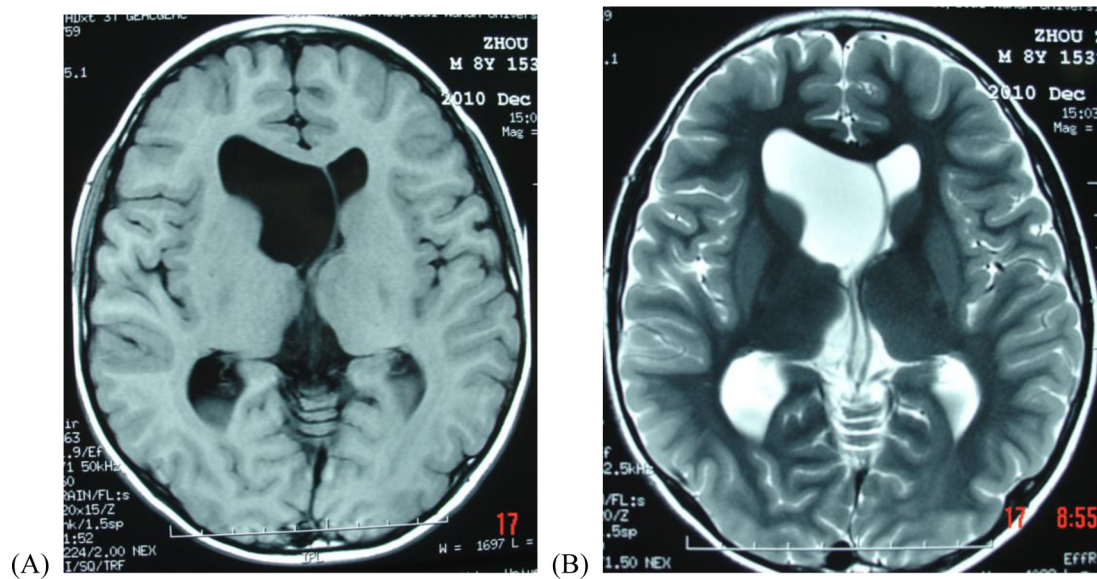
Preoperative axial T1-weighted and T2-weighted MR imaging sequences (A and B) show enlargement of right lateral ventricles accompanied by contralateral displacement of the septum pellucidum.
